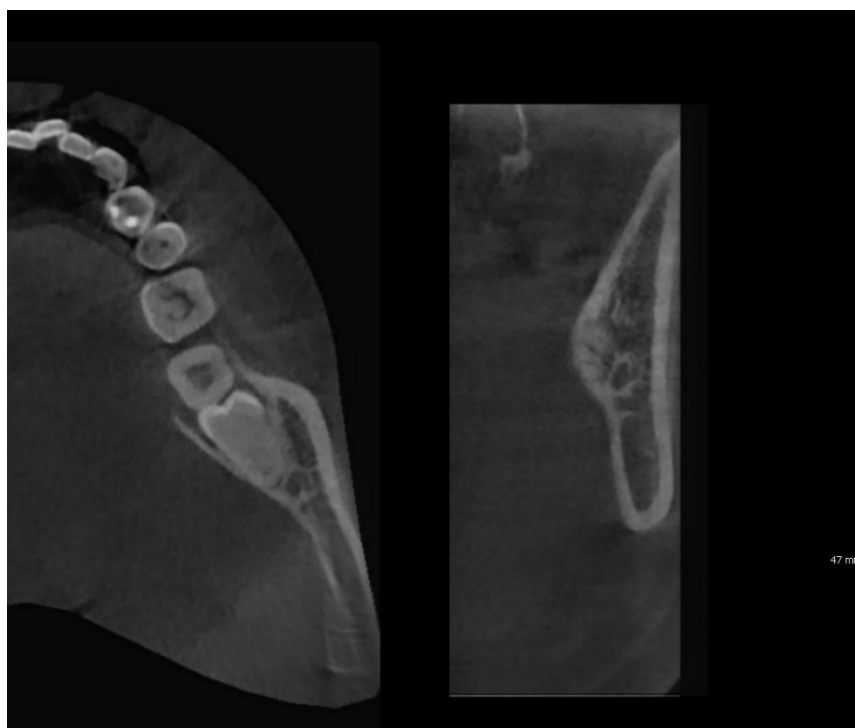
Patient 1801222, the CBCT confirms the nearness of the root of the wisdom tooth with the lingual cortical plate with an impaction of -1 mm. Axial plan on the left and cross-section plan on the right.
